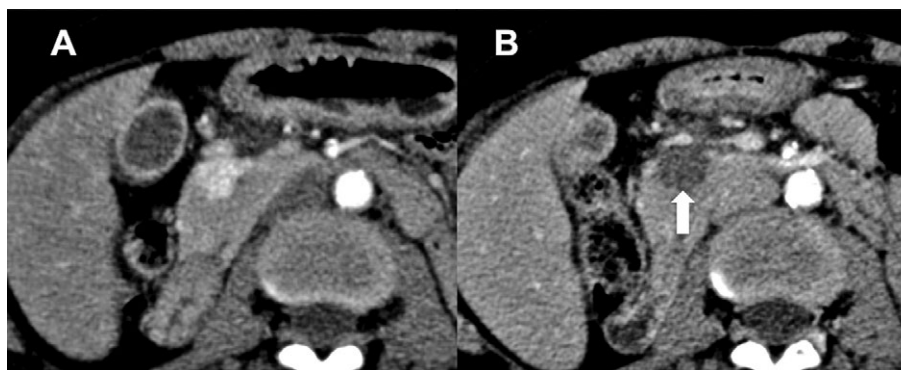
(A) A case of pancreatic head hypervascular metastasis from renal cell carcinoma. (B) After endoscopic ultrasound-guided radiofrequency ablation, a markedly hypodense area is detectable instead of the tumor (arrow).
